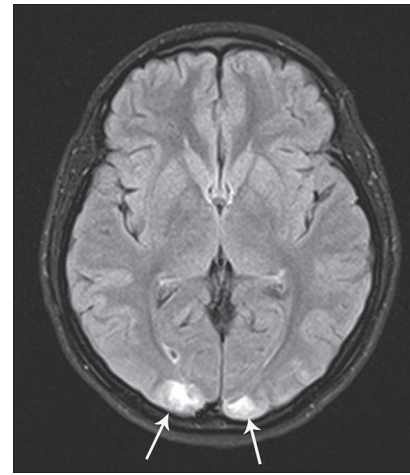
Axial MR image (fluid attenuation inversion recovery) showing edema in subcortical white matter (Grade 2) seen as hyperintensities in bilateral occipital lobes (patient 9)
